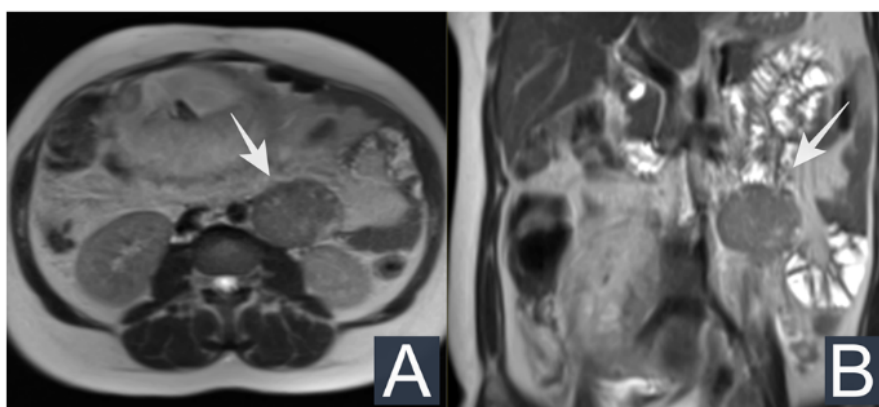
A: Axial turbo spin echo (TSE) plane, T2-weighted; and B: Coronal TSE plane, T2-weighted. The figures show a predominantly solid lesion (arrows), with a heterogeneous sign and partially defined contours. It is located in the retroperitoneum, along the pericaaval chain. It presents a clear plane of cleavage with the aorta and with the left kidney.
